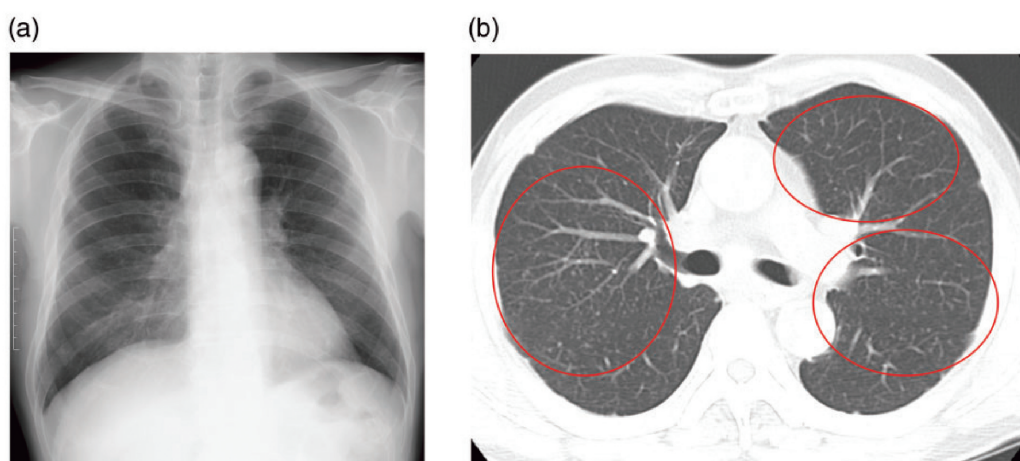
(a) A 72-year-old man with an exposure duration of 30 years. Chest radiography was judged as profusion 0/1. (b) Computed tomography images revealed many small opacities in the lung parenchyma (circles).
